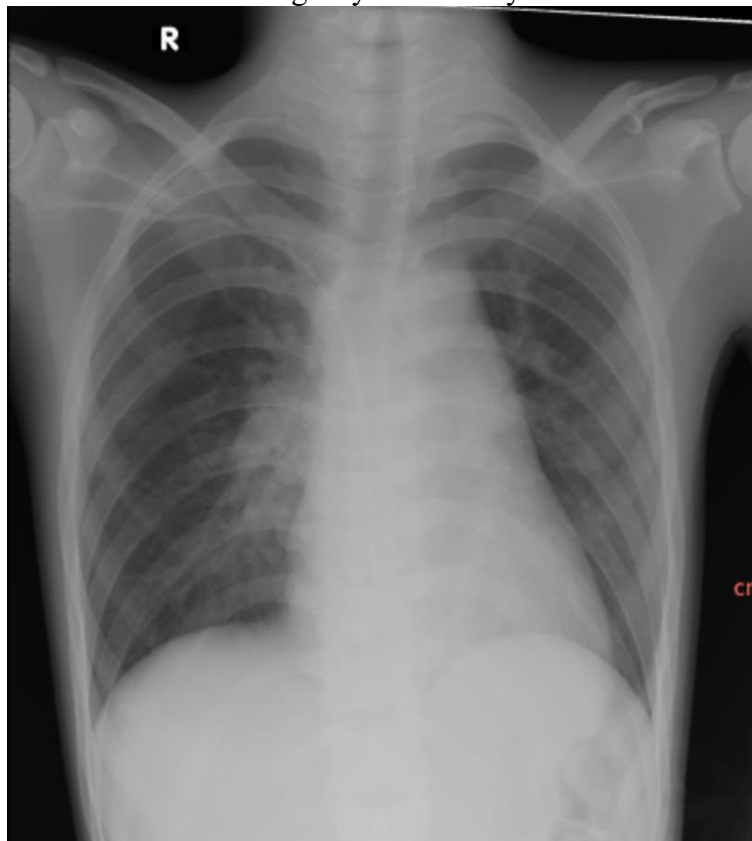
Chest X-Ray Findings showed a fracture of left clavicle bone
